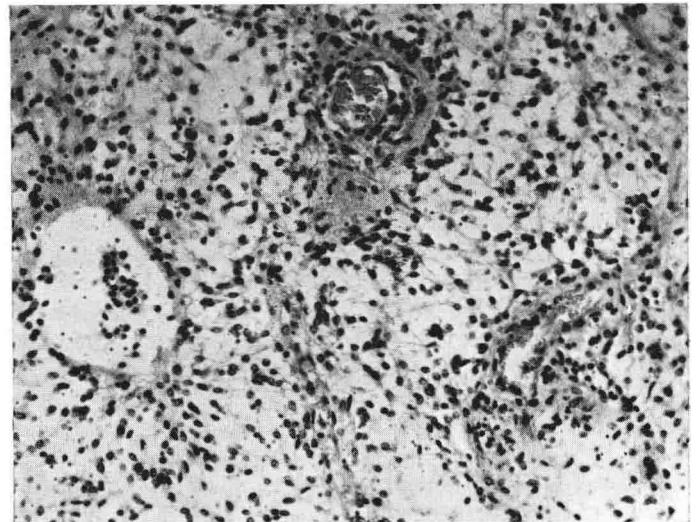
Posterior fossa protoplasmic astrocytoma showing spongy texture, microcystic degeneration and astrocytes about the vasculature. Tumour of 2-year-old female child; partial removal of lesion followed by deep X-ray therapy. Child alive and well now, aged 12 years. (H. & E.) $\times 140$. 26629 (Courtesy of Dr Peter H. Buxton.)
